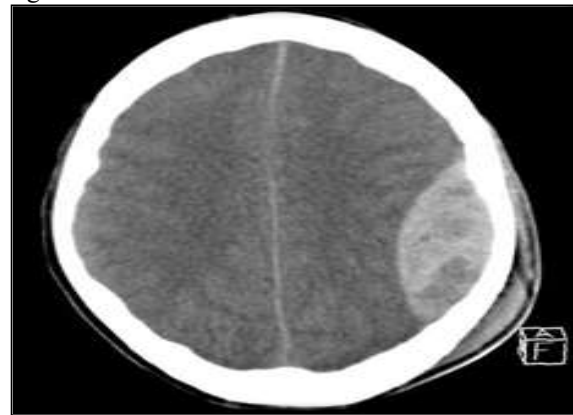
Axial CT brain showing a biconvex (lentiform) hyperdense extra-axial collection in the temporoparietal region (arrow), consistent with extradural hematoma. No significant association with mortality was observed in our study
